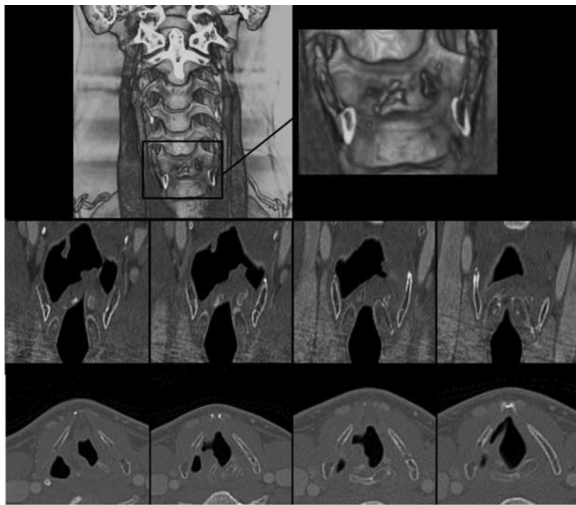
CT-scan: axial & frontal view and 3D reconstruction showing the displacement and the dislocation of the right arytenoid.
